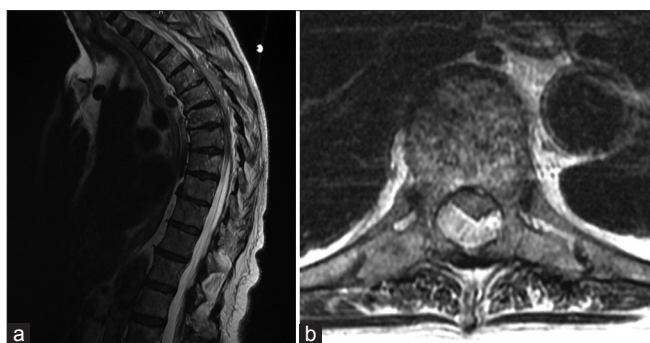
(a) Sagittal T2 magnetic resonance imaging (MRI) show severe spinal cord compression at T5, (b) axial T2 MRI show severe spinal cord compression at T5.
